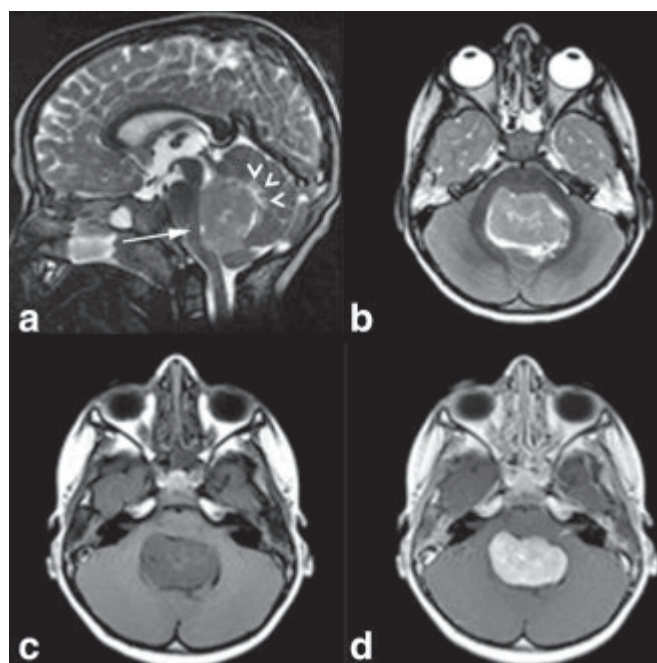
Medulloblastoma. Sagittal and axial T2-weighted (a,b) and axial pre- and postcontrast T1-weighted MR images (c,d) of a 6-year-old boy with classical medulloblastoma. The mass lesion is located in the midline dorsally to the fourth ventricle and pushes the fourth ventricle anteriorly (arrow on a). The tumor is moderately T2-hyperintense to the cerebellar and brainstem gray matter and shows a strong contrast enhancement. Mild perifocal T2-hyperintense edema is seen within the vermis, dorsally to the tumor (white arrowheads on a) (Journal of Magnetic Resonance Imaging Volume 35, Issue 1, pages 32-47, 11 OCT 2011 DOI: 10.1002/jmri.22722 <http://onlinelibrary.wiley.com/doi/10.1002/jmri.22722/full#fig4>).
